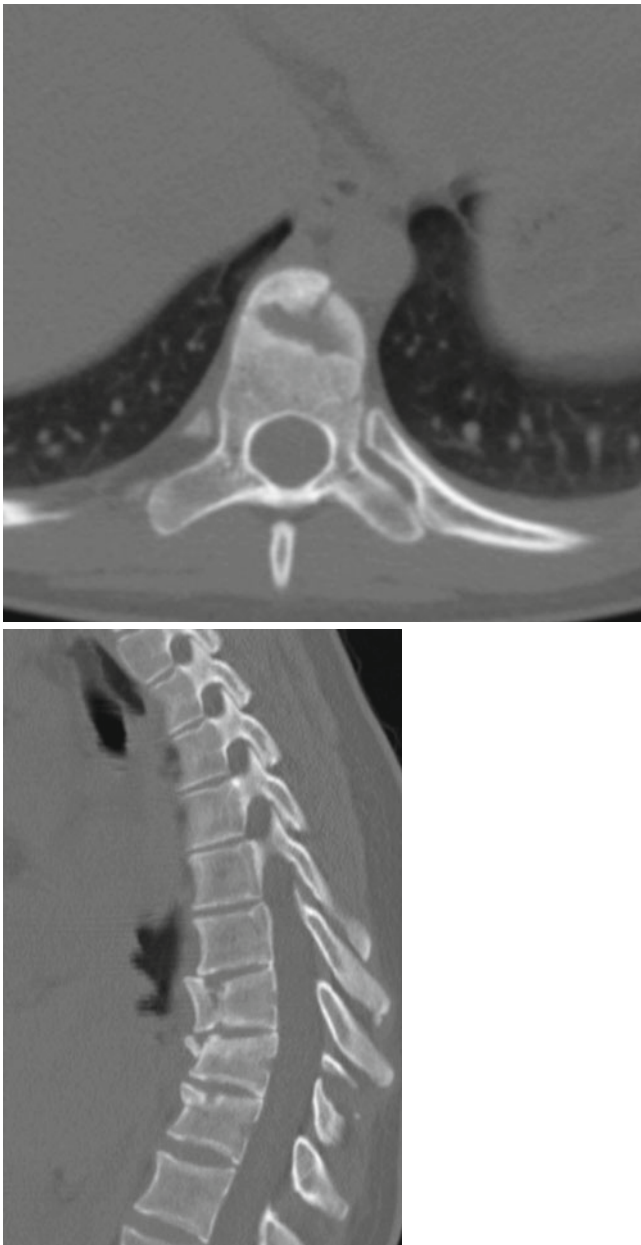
Preoperative CT thoracic spine—axial (*top*) and sagittal (*bottom*) slice demonstrating sagittal and coronal split fractures of the thoracic vertebral body
